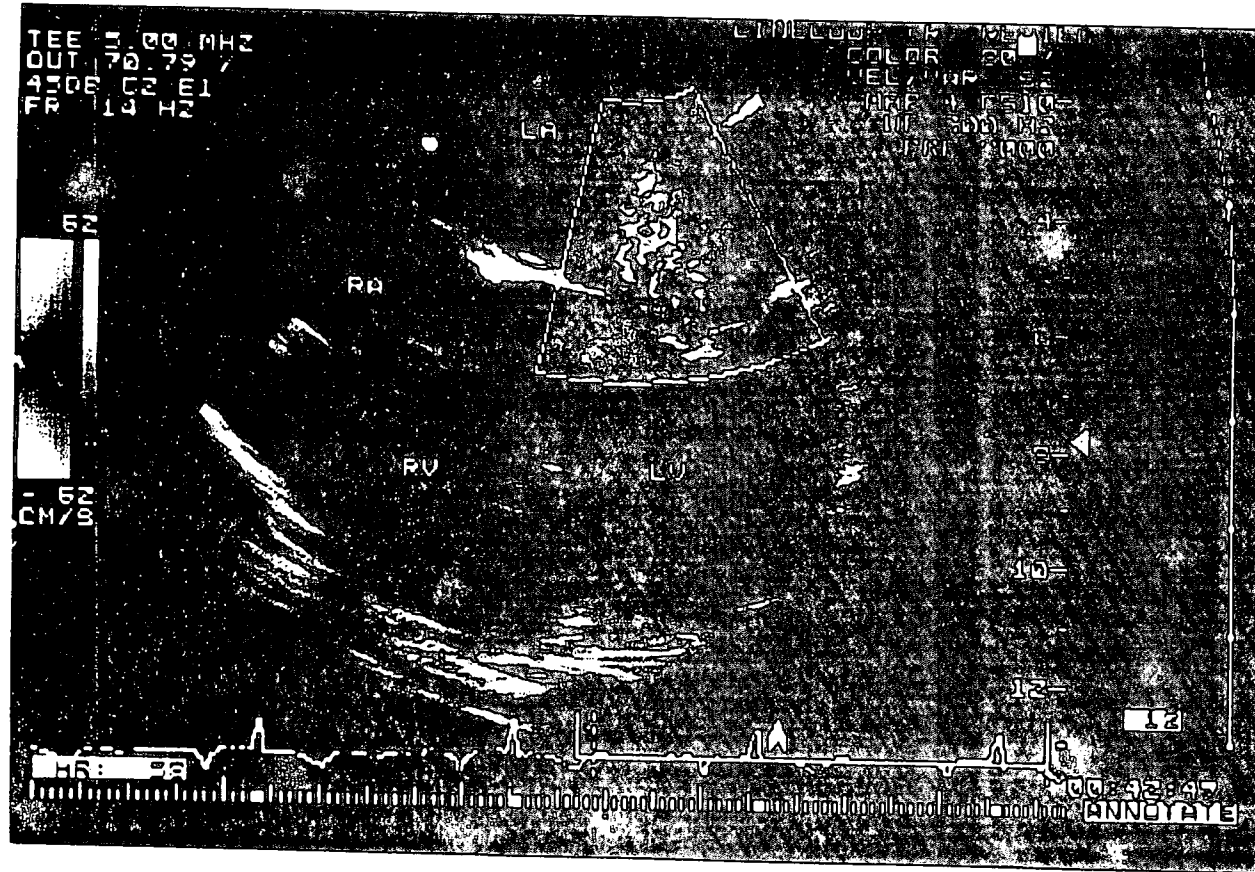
Mitral regurgitation was graded in the 4 chamber view according to the area covered by the Doppler color flow jet.
